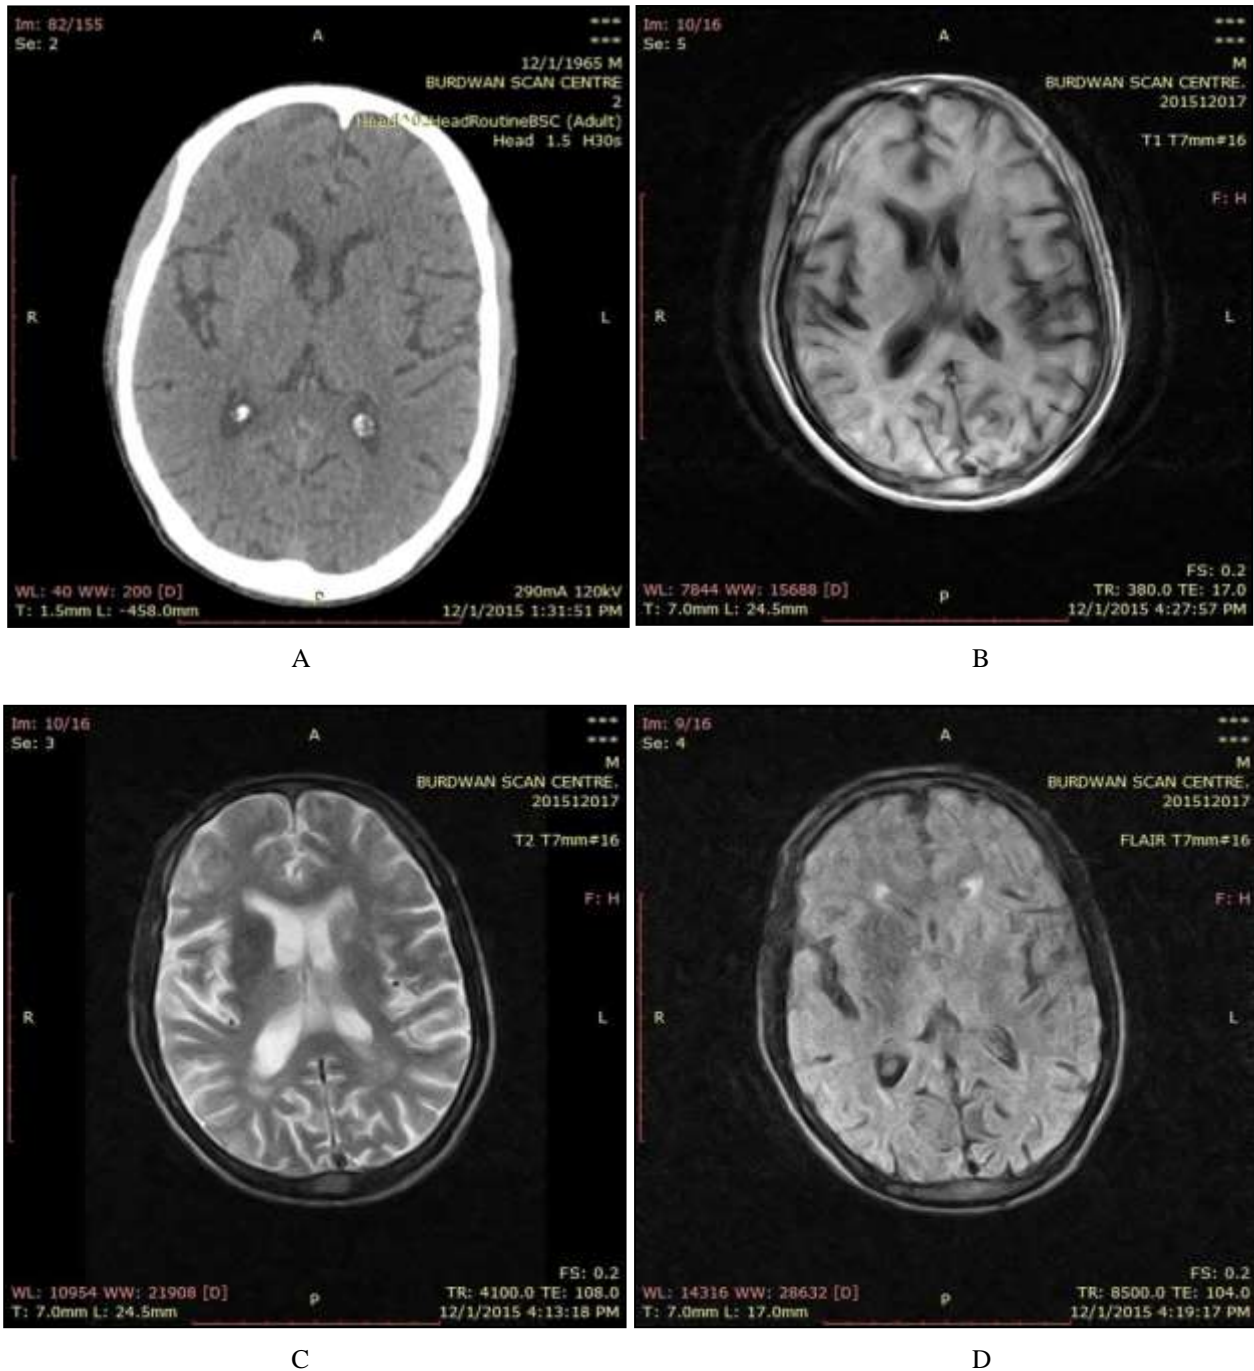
(A) CT showing hyperdense right putamen and caudate head.
